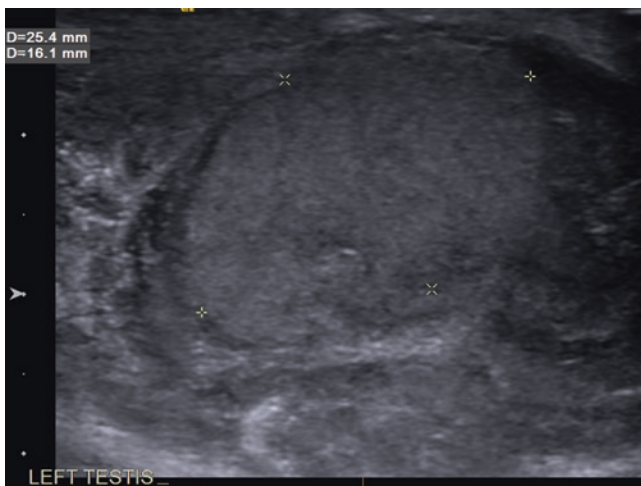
Longitudinal ultrasound image of the left testis, showing a rounded hyperechoic collection in the testis, consistent with haematoma
